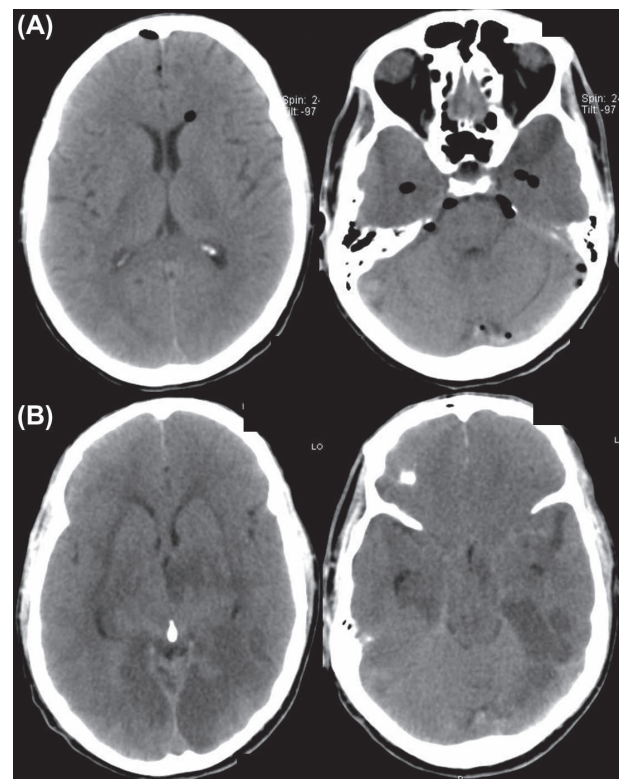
Early CT scan showing post-operative cerebral pneumocephalus (2A), and 72-h CT scan showing generalised ischaemic changes (2B).
